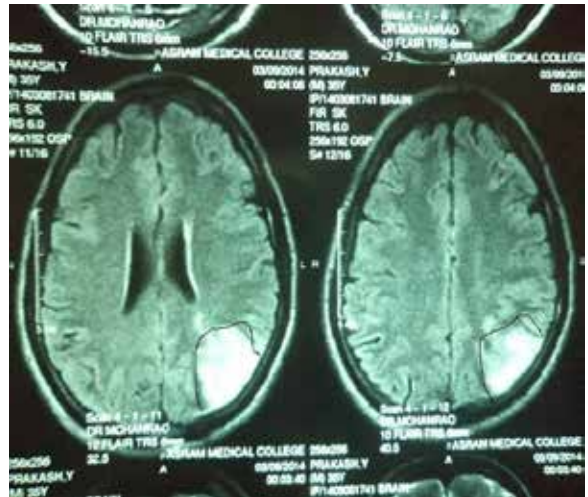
MRI SCAN OF THE PATIENT, Acute infarct in posterior watershed area
